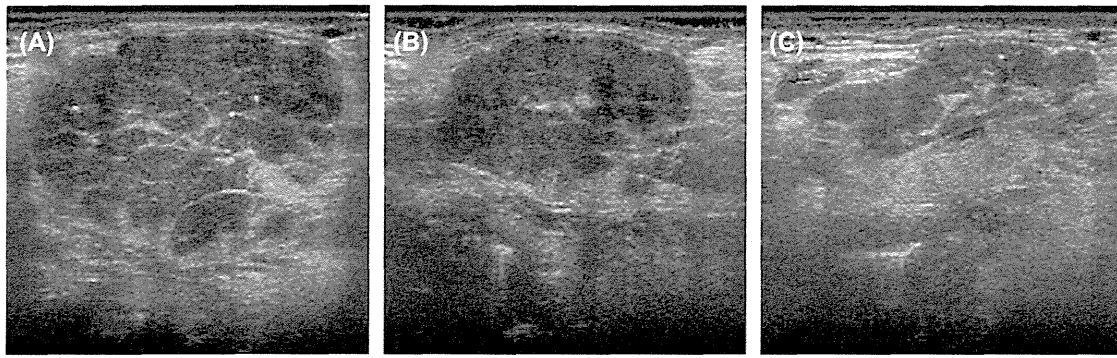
Ultrasonography findings of submandibular glands. A huge nodular lesion of the submandibular gland was observed (A). Two weeks after glucocorticoid therapy, the size of the hypoechoic area was slightly diminished (B). Two months after the initiation of treatment, the size of the hypoechoic area decreased (C).
